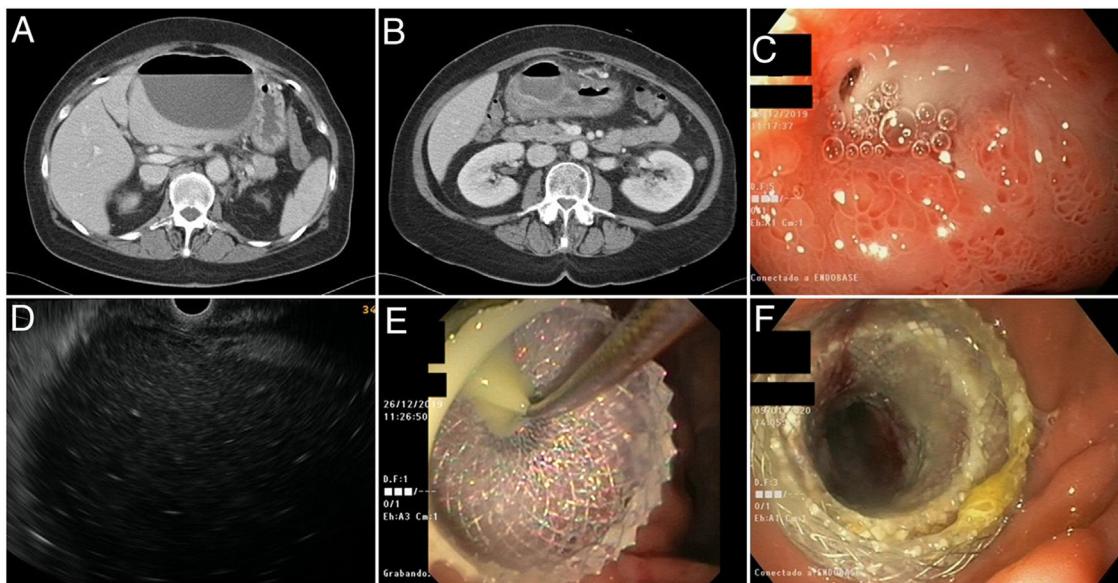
A-B) Abdominal CT images showing a large hypodense collection with an air-fluid level compatible with abscess, showing contact with the left lobe of the liver and with the gastric antrum. C) First gastroscopy. Duodenal bulb ulcer with a hole in its interior suggestive of perforation. D) Endoscopic ultrasound image of the abdominal collection from the gastric antrum. E) Moment of placement of the Hot-Axios® lumen-apposing stent with drainage of purulent material. F) Check-up after one week; open stent allowing access to a cavity now free of purulent material.
